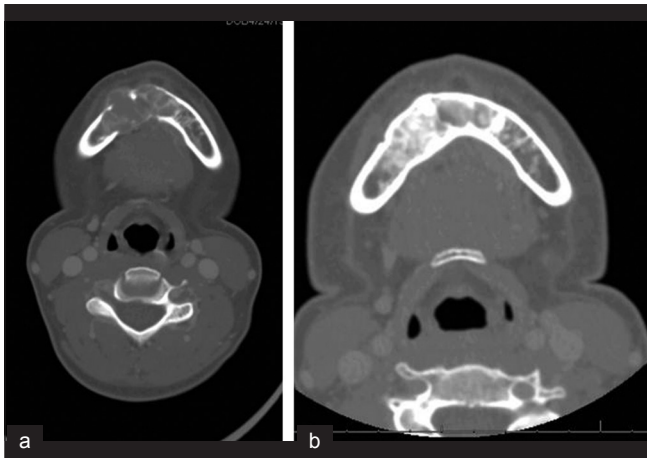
CT scan of a central giant cell granuloma of the anterior mandible (a) Prior to commencing calcitonin, and (b) after 18 months of subcutaneous calcitonin. Note the increased calcification (images courtesy of Mehran Hossaini DMD)
